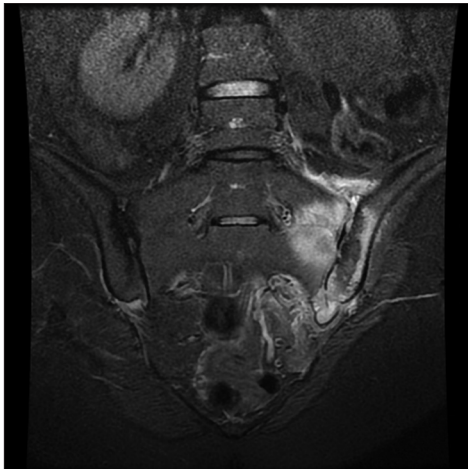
Magnetic Resonance Image showing bilateral sacroiliitis
